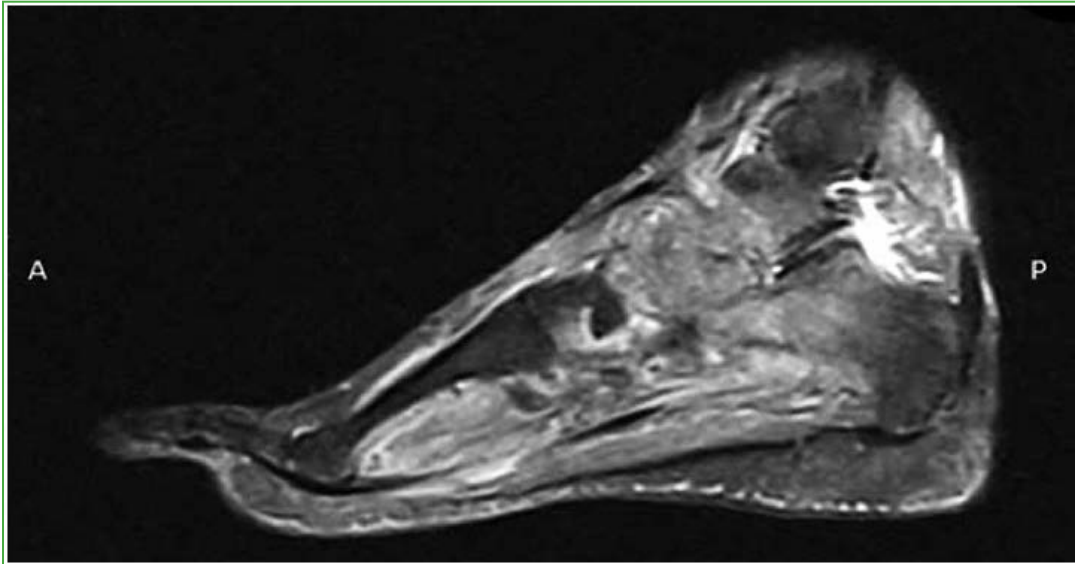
Magnetic resonance imaging of the foot and ankle, sagittal image. Trabecular fractures of the talus and calcaneus, an approximately 35-mm fluid collection adjacent to the posterior tibial tendon, and infectious-inflammatory changes are observed.
